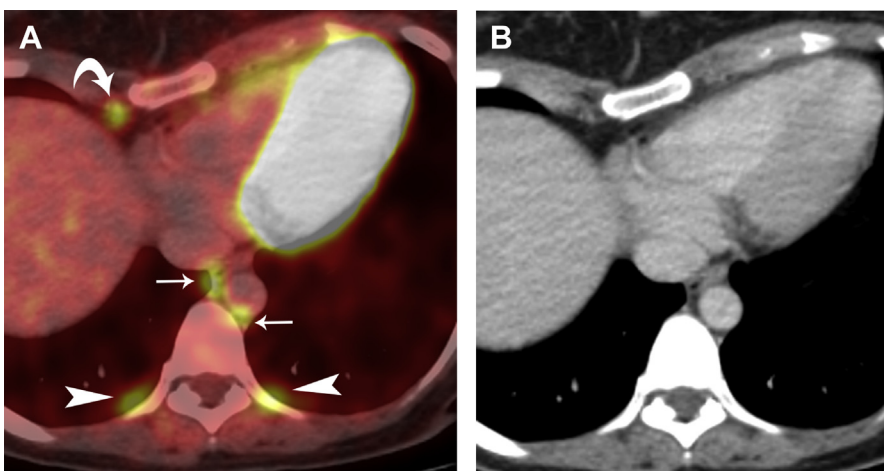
Brown adipose tissue in a 34-year-old woman undergoing follow-up imaging related to melanoma. (A) A fused axial FDG PET/CT scan shows foci of increased FDG uptake in the prevascular mediastinum (*curved arrow*), adjacent to the azygous and hemiazygous veins (*arrows*), and in the bilateral paraspinal regions (*arrowheads*). (B) A contrast-enhanced axial CT scan of the chest localizes these foci of increased FDG uptake to areas of fat. No lymph nodes were identified in these regions. Deposits of brown adipose tissue can show increased FDG uptake on PET/CT scans owing to cold stimulus.
